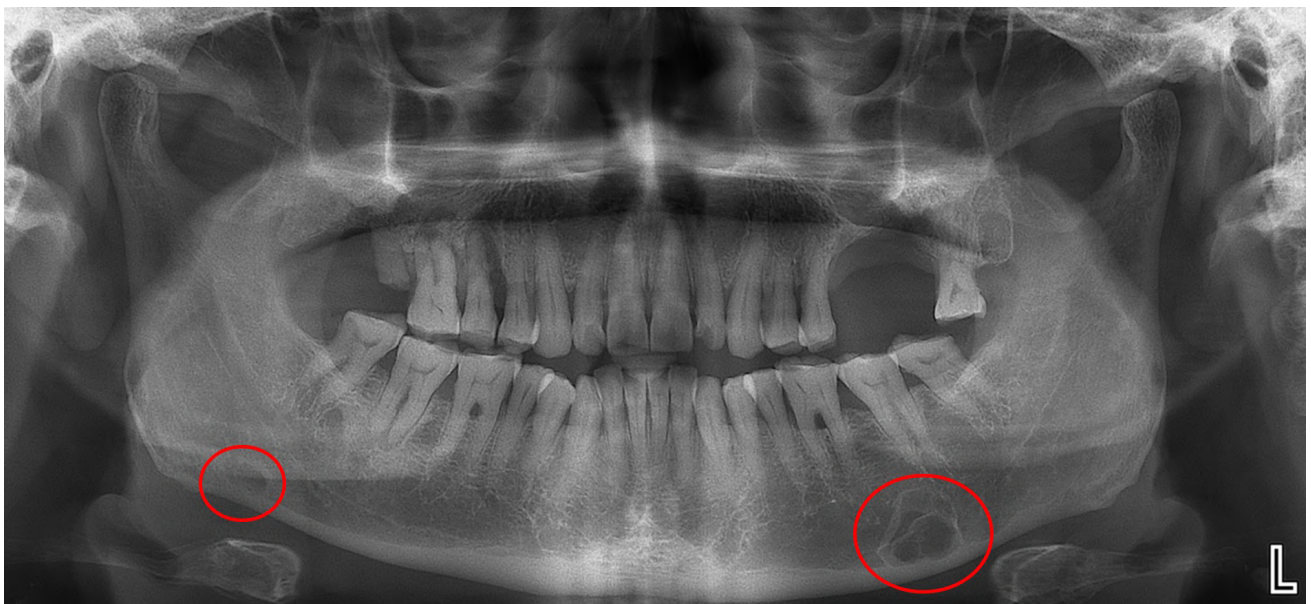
Orthopantomography representing bilateral radiolucency below the inferior alveolar canal; right side shows unilocular radiolucency, left side shows multilocular radiolucency.
